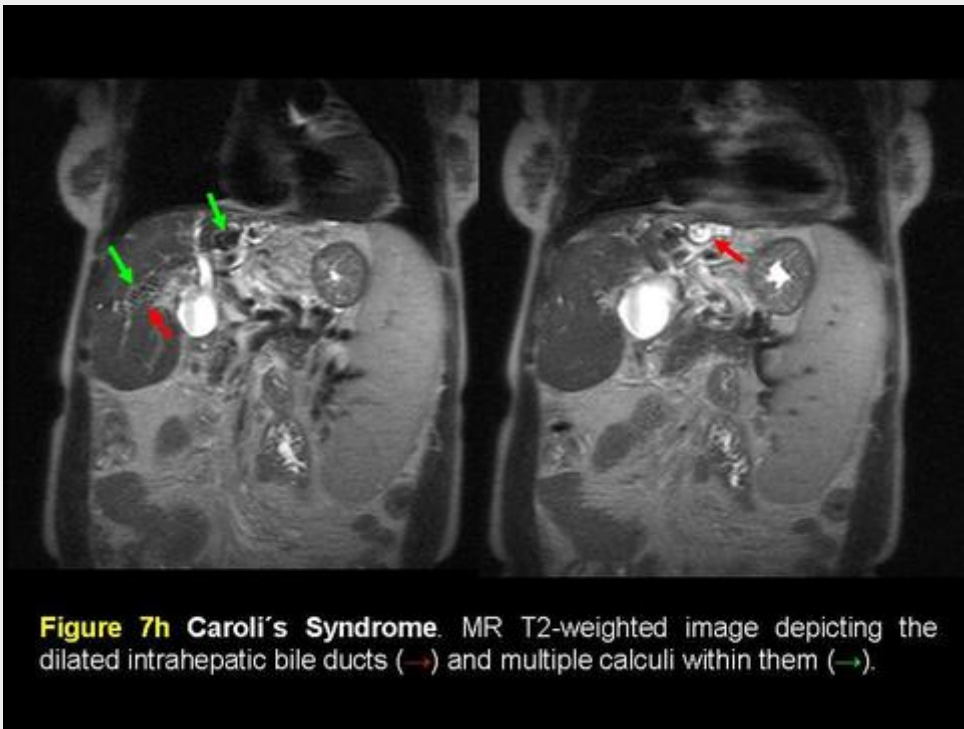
Caroli's Syndrome. MR T2-weighted image depicting the dilated intrahepatic bile ducts (→) and multiple calculi within them (→).
